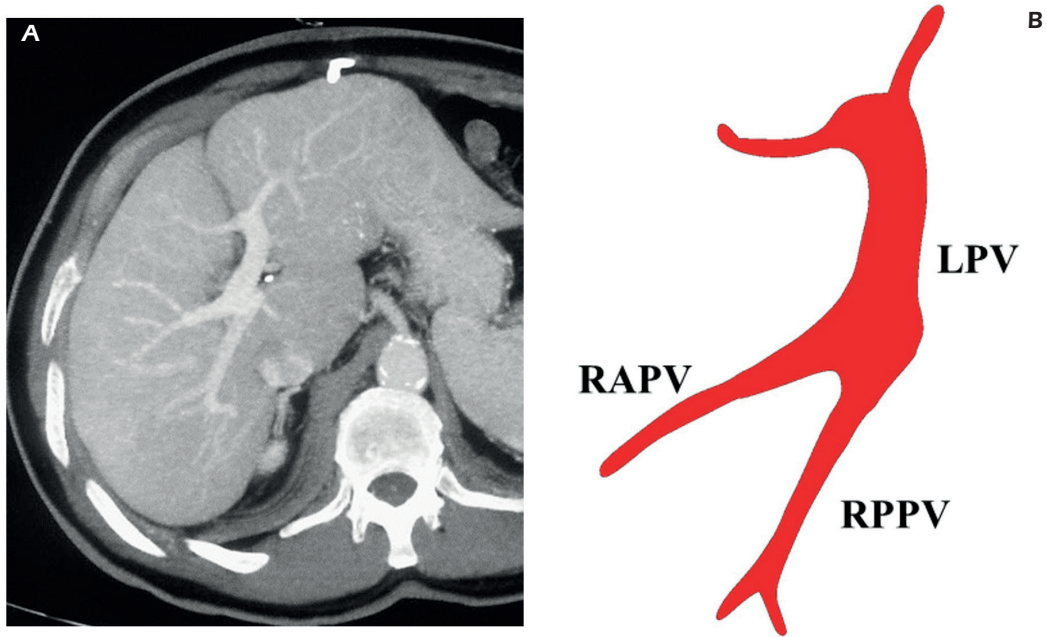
Portal vein variants – type 1: portal vein trifurcation. A, Contrast-enhanced CT on portal venous phase – axial MIP reconstruction. The main portal vein divides into three branches: the left portal vein, the right anterior portal vein, and the right posterior portal vein. B, LPV: left portal vein; RAPV: right anterior portal vein; RPPV: right posterior portal vein.
